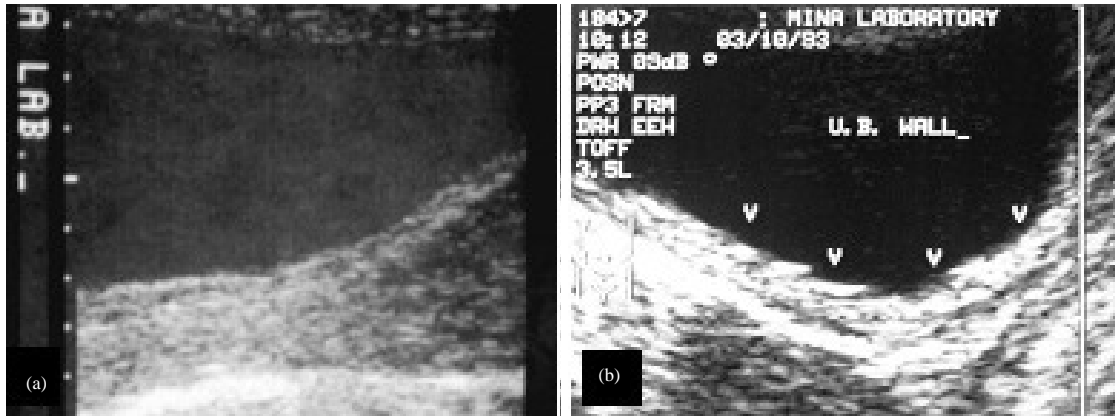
(a-b): (a) Acute cystitis, in severe cases, the three-layer sign of the bladder wall and debris in the urine are seen and (b) Recurrent cystitis. On ultrasonographic examination, the bladder inner wall is found to be irregular
